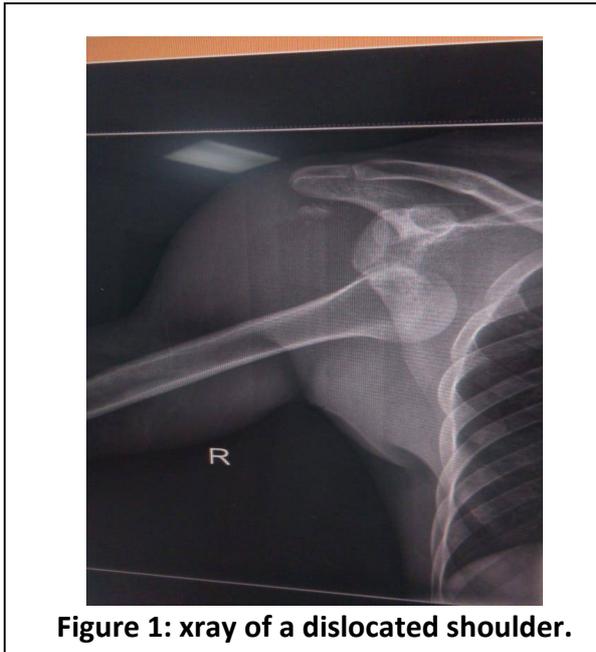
xray of a dislocated shoulder.
